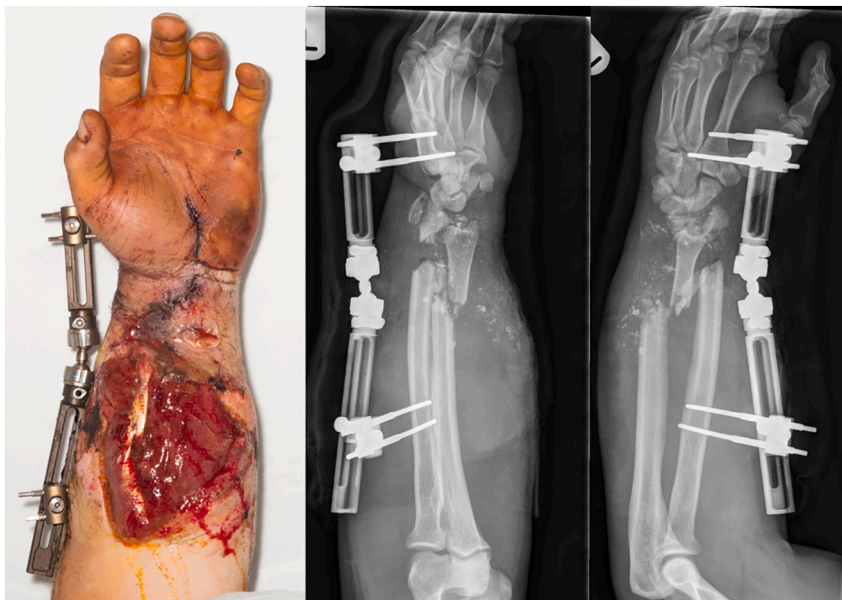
Clinical photographs and x-rays on presentation to our unit.
